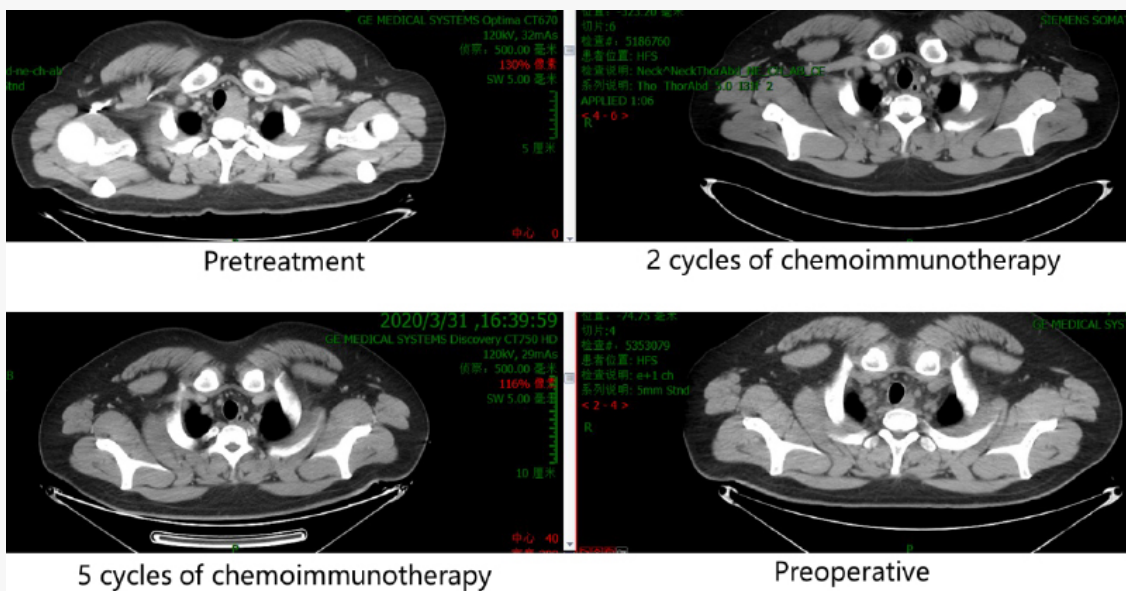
Reassessment of thoracic esophageal lesions by CT
